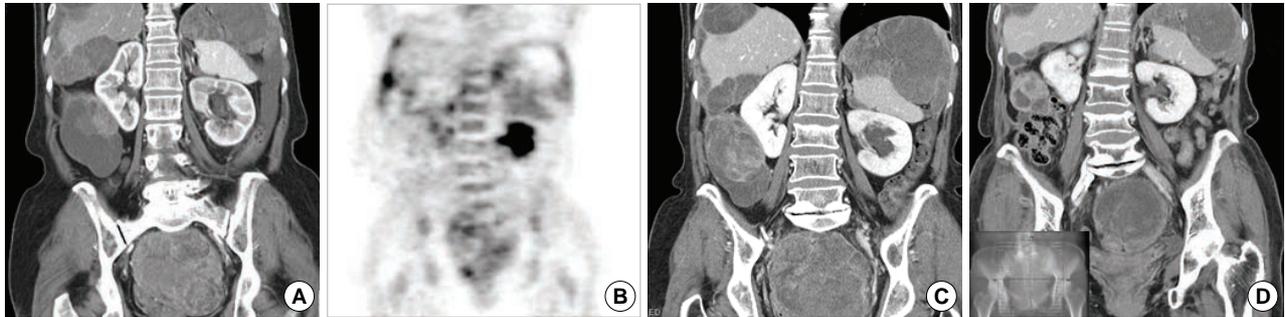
Images before and after treatments. (A) A CT scan performed before systemic chemotherapy shows multiple metastatic masses in the abdomen and pelvis. (B) A PET scan performed before systemic chemotherapy shows multiple hypometabolic masses in the abdomen and pelvis. (C) A CT scan performed before radiotherapy and hormonal therapy shows multiple metastatic masses with increased size in the abdomen and pelvis. (D) A CT scan performed after radiotherapy and hormonal therapy shows a partial response to this therapy. The insert shows a radiotherapy planning radiography.
